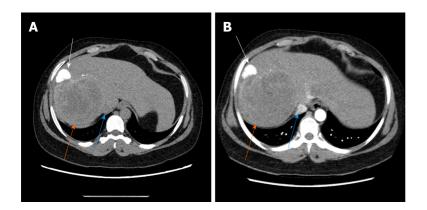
The fourth case of abdominal enhancement computed tomography. A, B: The white arrow shows cystic hydatid foci in high density, the orange arrow shows alveolar hydatid foci in low density, and the blue arrow shows posterior inferior vena cava in equal density.
